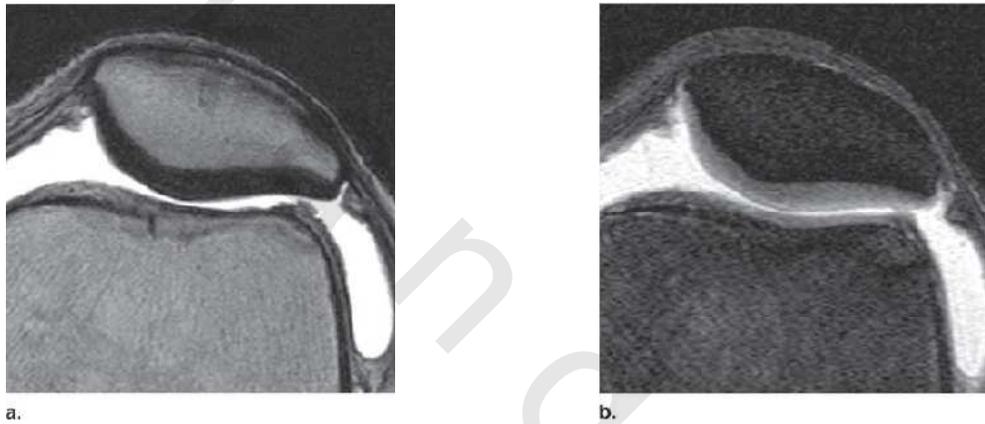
(a) Axial 2D T2-weighted non-fat suppressed fast SE image provides excellent contrast between cartilage surfaces and synovial fluid, but the cartilage is poorly depicted with diffuse low signal intensity, and there is no contrast between cartilage and cortical bone. (b) Axial 2D intermediate-weighted fat suppressed fast SE image shows excellent contrast among cartilage surfaces, synovial fluid, and subchondral bone, as well as variation of signal intensity within the cartilage.⁽⁵²⁾
